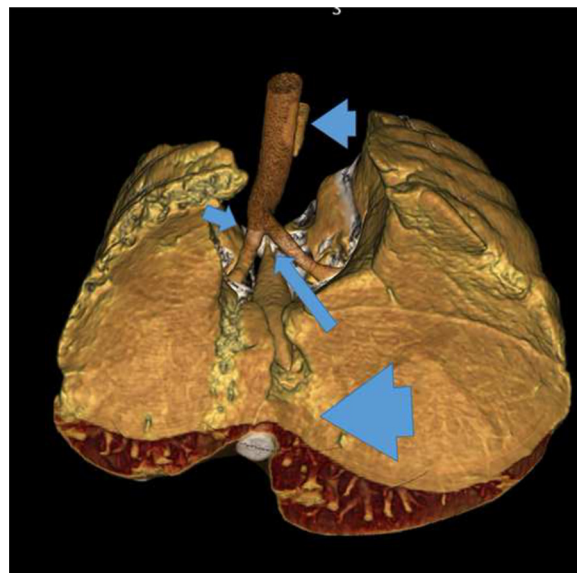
3D reformat of chest CT angiography shows esophageal atresia (small arrowhead) with the distal esophageal segment originated from the tracheal carina (long arrow), absence of the right upper bronchial bronchus (short arrow) and horseshoe lung (large arrowhead).
